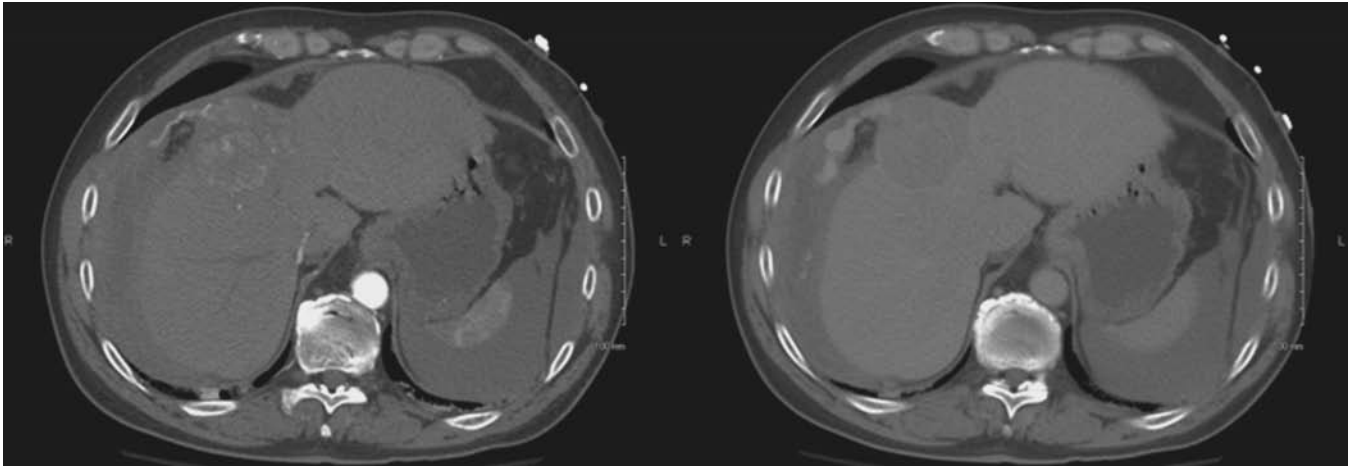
Computed tomographic appearance of ruptured hepatocellular carcinoma. Note the acute extravasation of contrast seen on early arterial phase images with pooling of blood seen on delayed images.
